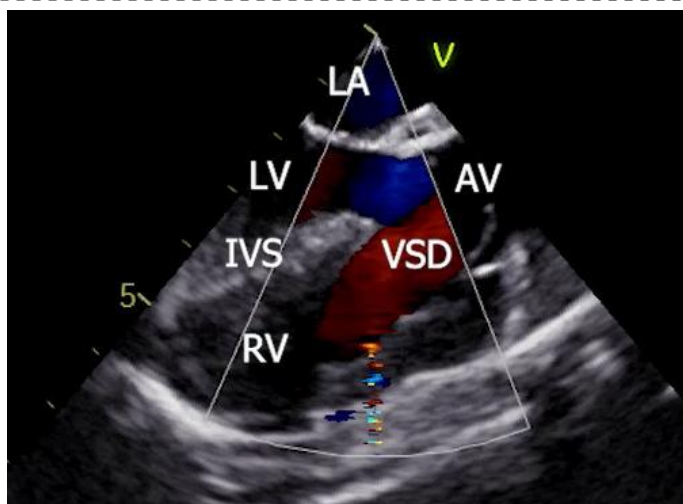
ME-LAX, TEE view at 121 Degree. The color doppler examination reveals large subaortic VSD with Bidirectional flow (red and blue jet) (Labelled).
